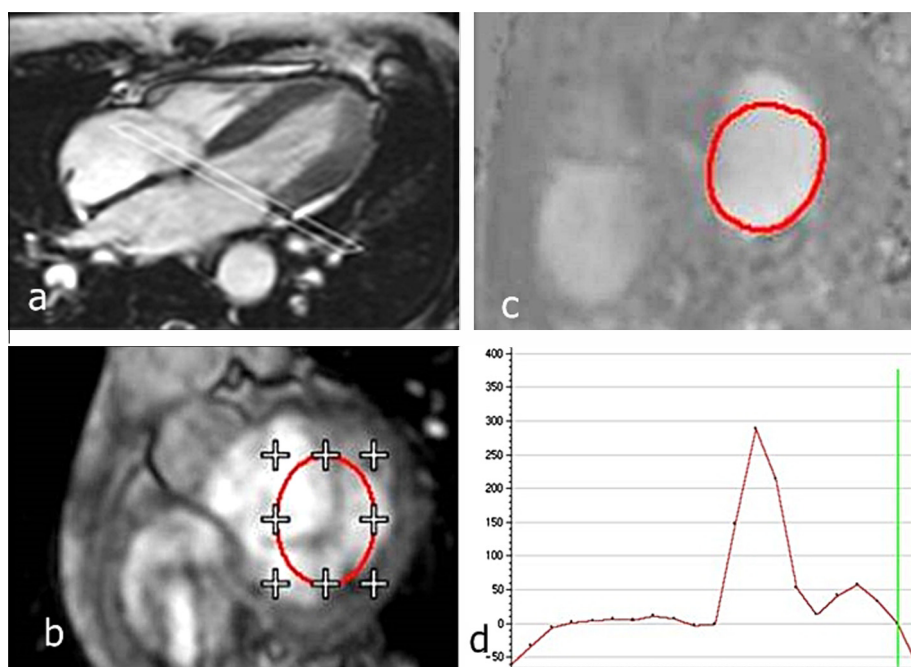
At end-systole, an acquisition plane is positioned at the mitral valve (a). Through-plane one-directional velocity-encoded MRI magnitude image (b) and velocity image (c) time-flow rate graph (d) of the same patient in Fig. 2 shows grade III diastolic dysfunction.
